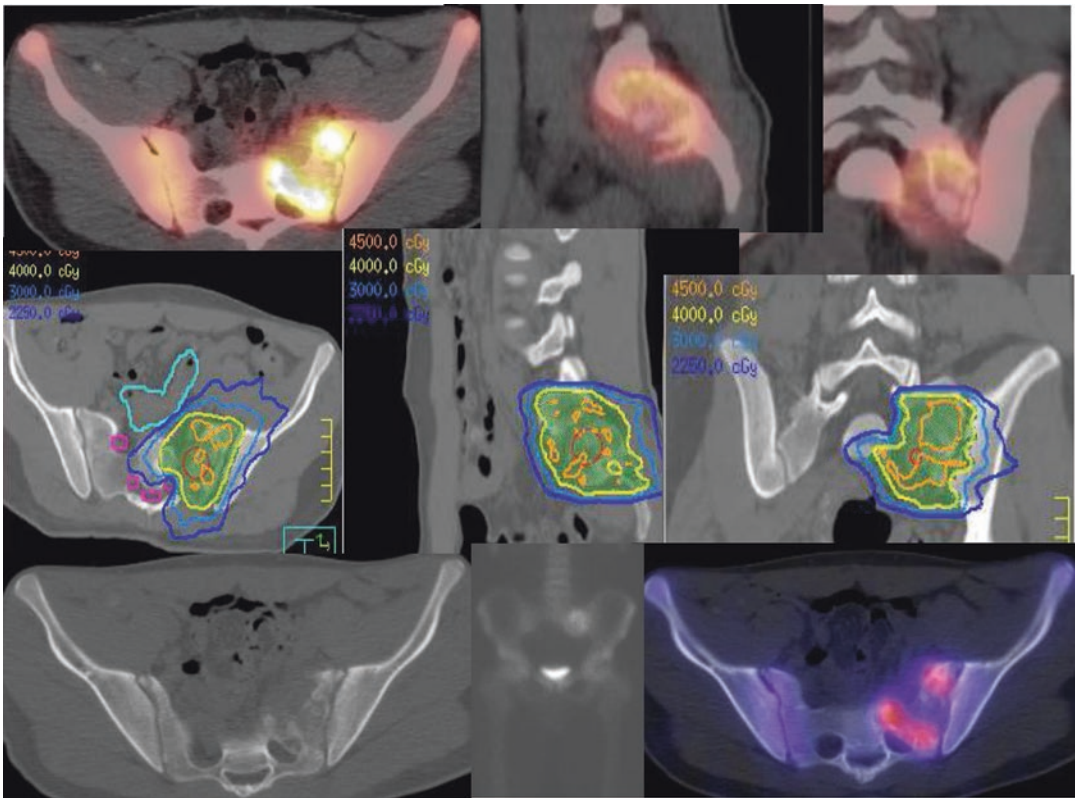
Scan images and SBRT plans of osteosarcoma involving sacrum treated with denosumab, pazopanib, and 223-radium. Top: PET-CT showing ¹⁸F-FDG activity; middle: SBRT plan (8 Gy × 5 = 40Gy; bottom: CT, planar
